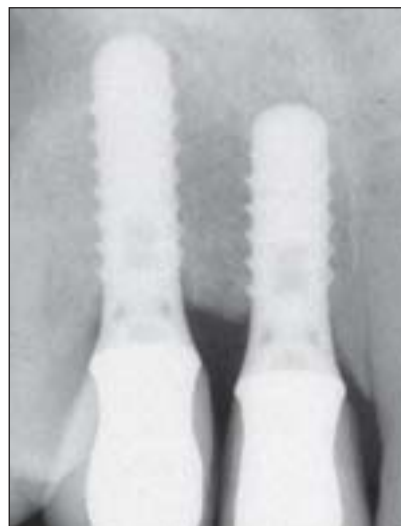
(Right) Periapical radiograph, taken 3 years after implant placement, shows minimal bone resorption around both implants.
